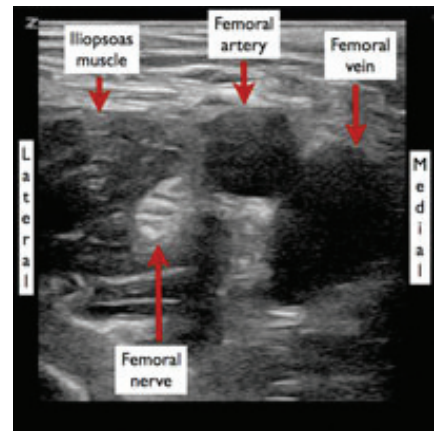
Transverse ultrasound view of femoral nerve and surrounding anatomy.
